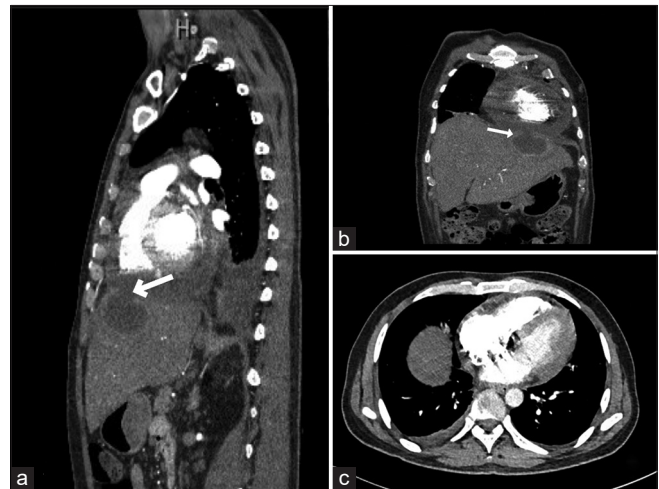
(a-c) Computed tomography (CT) angiography of the abdomen and thorax CT angiographic cuts demonstrate a ruptured hepatic abscess in segment 2 with a connection to the pericardium. The findings include a coalesced hepatic lesion measuring 6 cm × 5 cm, with a spontaneous rupture into the pericardium, resulting in a pericardial effusion measuring up to 24 mm with peripheral enhancement. A subcapsular hepatic abscess is noted, which contains an internal air bubble measuring 16 mm × 11 mm, along with multiple ring-like nodular enhancements suggestive of hepatic microabscesses. Segmental portal vein thrombosis involving the right hepatic segments is evident, accompanied by mild bilateral pleural effusions that are more prominent on the right side (Arrow shows ruptured hepatic abscess)
